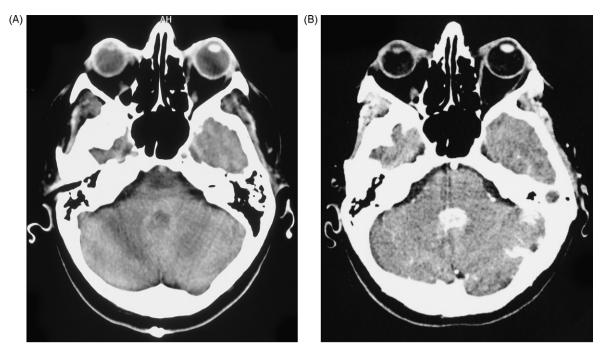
Preoperative non-contrast enhanced (A) and contrast enhanced (B) axial CT scan showing a hyperdense mass lesion with marked homogeneous contrast enhancement in the fourth ventricle.
